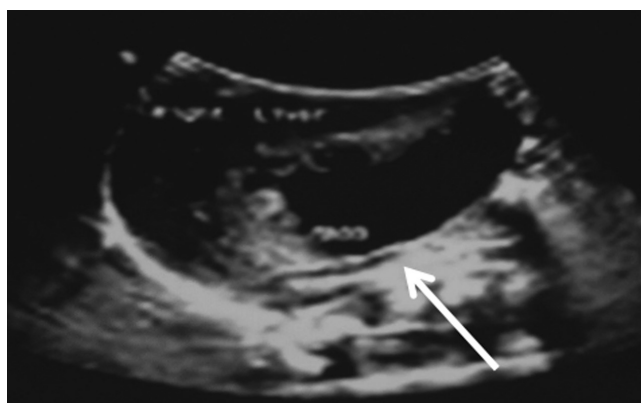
Ultrasound image of the right lobe of the newborn's liver shows a heterogeneous mass-like lesion on Day 2.
